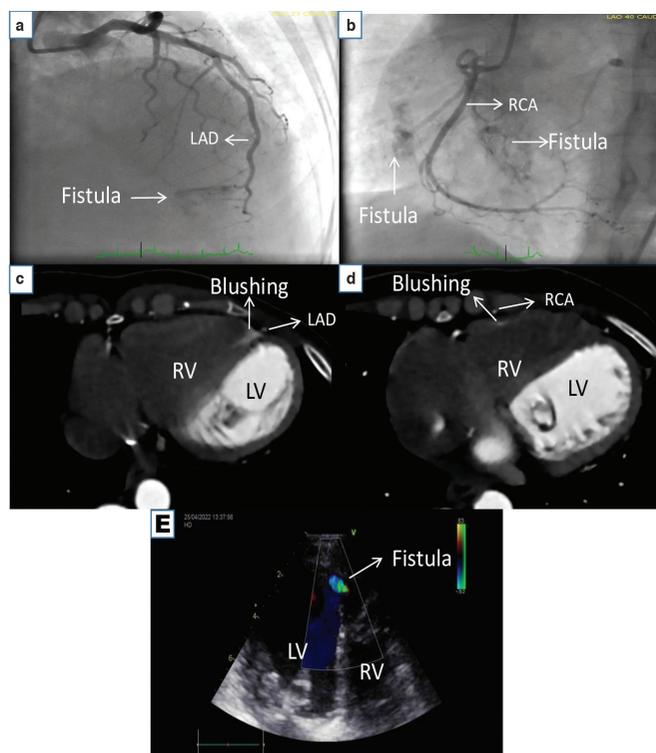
(a) Coronary-cameral fistula originating from the septal perforating branch of the left anterior descending (LAD) artery on coronary angiogram. (b) Coronary-cameral fistula originating from the conus branch of the right coronary artery (RCA) on coronary angiogram. (c) Fistulous connection between the LAD and right ventricular (RV) cavity on computed tomography. (d) Fistulous connection between the RCA and RV cavity on computed tomography. (e) A jet flow toward the RV cavity on transthoracic echocardiography.
